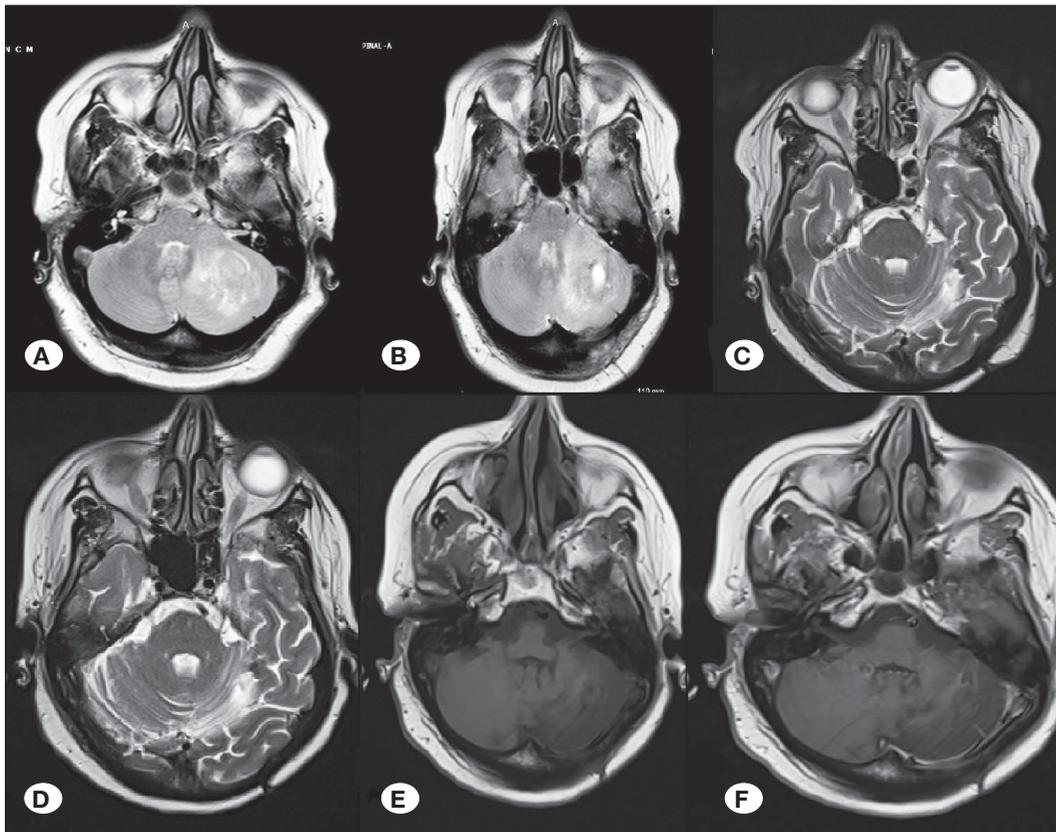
A) A lateral cerebellar mass is visible in the axial section of T2W magnetic resonance imaging (MRI) scan. B-C) Postoperative follow-up cranial axial T2W MRI scans show a residual mass less than 1.5 cm. No recurrence or residual disease is noted on the fifth year follow-up cranial MRI scans (D: axial T2W, E and F: axial T1W contrast enhanced).
